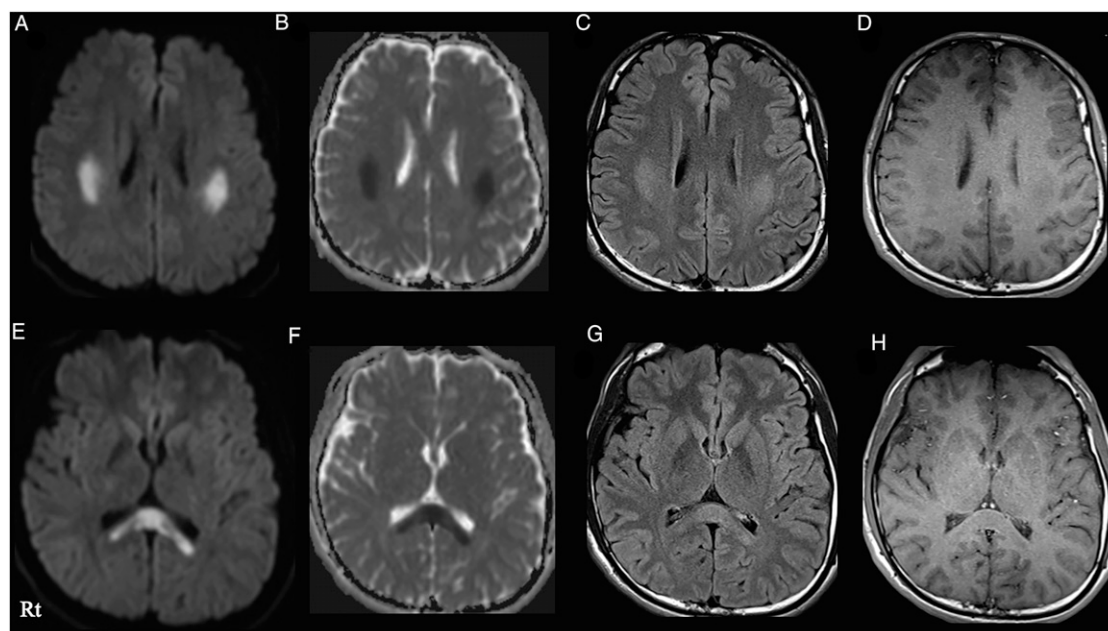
Diffusion-weighted magnetic resonance imaging (MRI) (panel a and e) demonstrated increased signal intensity, and the apparent diffusion coefficient (ADC) map (panel b and f) revealed decreased water diffusivity in both the white matter and splenium. The lesions showed the hyperintensities on fluid attenuated inversion recovery and slightly decreased intensities on T1-weighted MRI.
